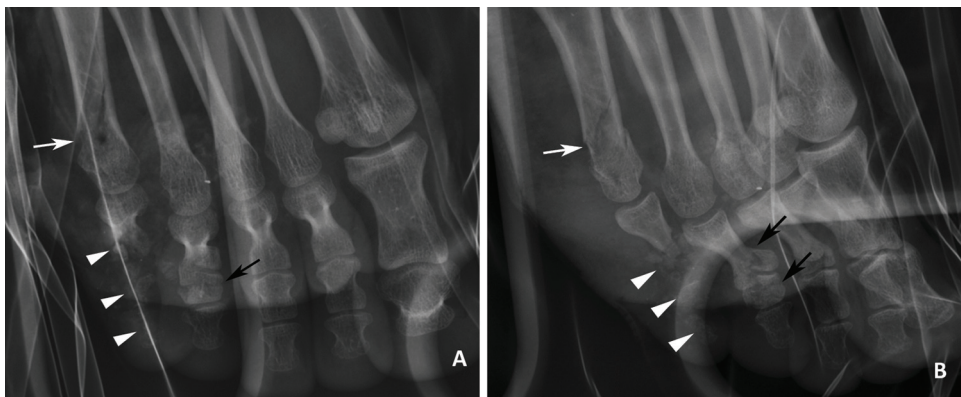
The conventional radiography of right ankle, AP (A) and oblique (B) views, in a 37-year-old female patient showed spiral fracture of the fifth metatarsal shaft (white arrow) and comminuted fractures of proximal, middle and distal phalanges of the fifth toe (white arrowhead) and proximal and middle phalanges of the fourth toe (black arrow). No sharpnel fragment was identified near the fracture site. These lesions were categorized as tertiary blast injuries.
